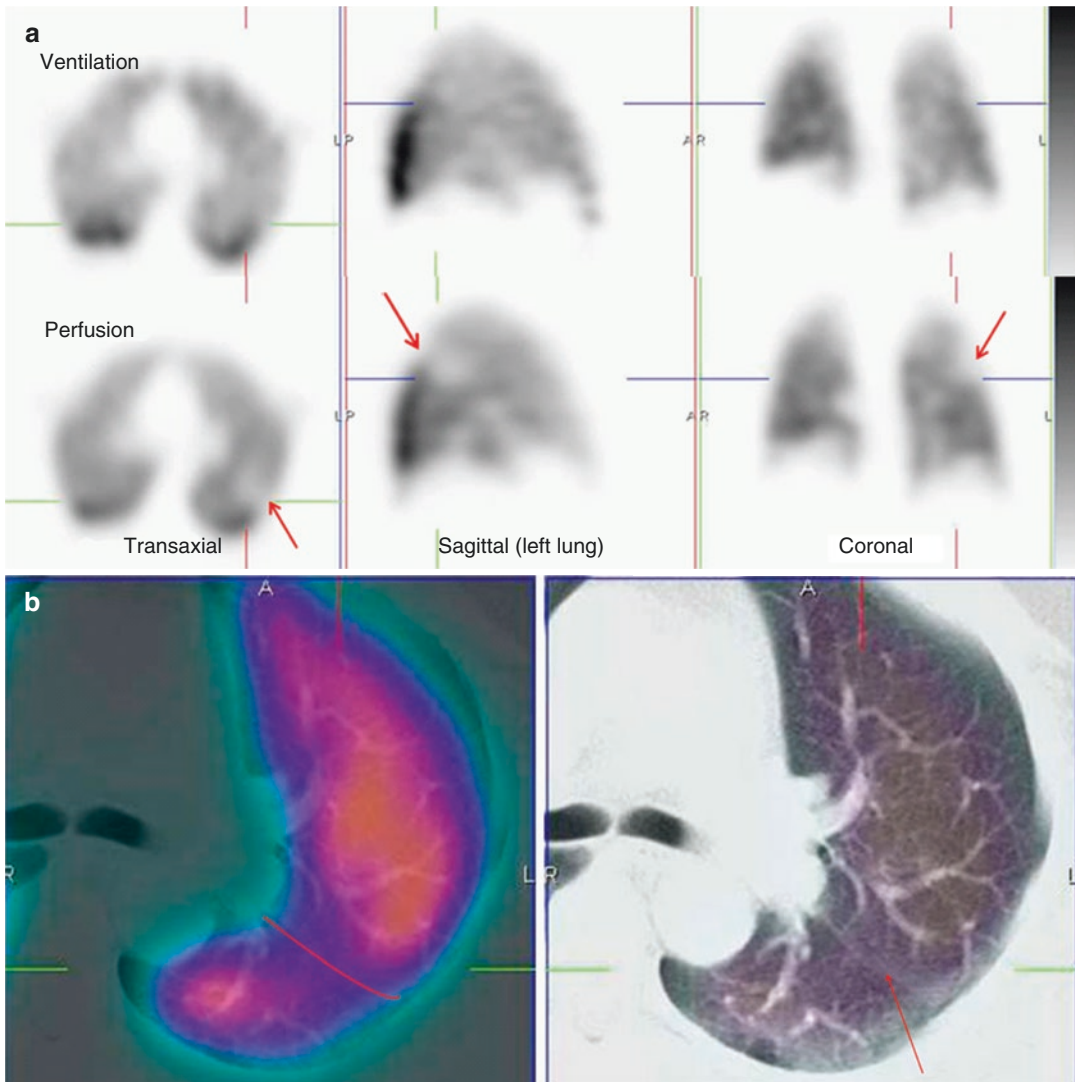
(a) Representative ventilation and perfusion SPECT images in a patient with suspected PE show a linear mismatch in the left upper/mid-zone (arrowed). This is non-segmental in appearance. (b) Fused perfusion SPECT/CT (left) and the (unfused) CT (right) of the left lung show the perfusion reduction to correspond with the oblique fissure (marked and arrowed in red). SPECT/CT helps to characterise the cause of SPECT perfusion
